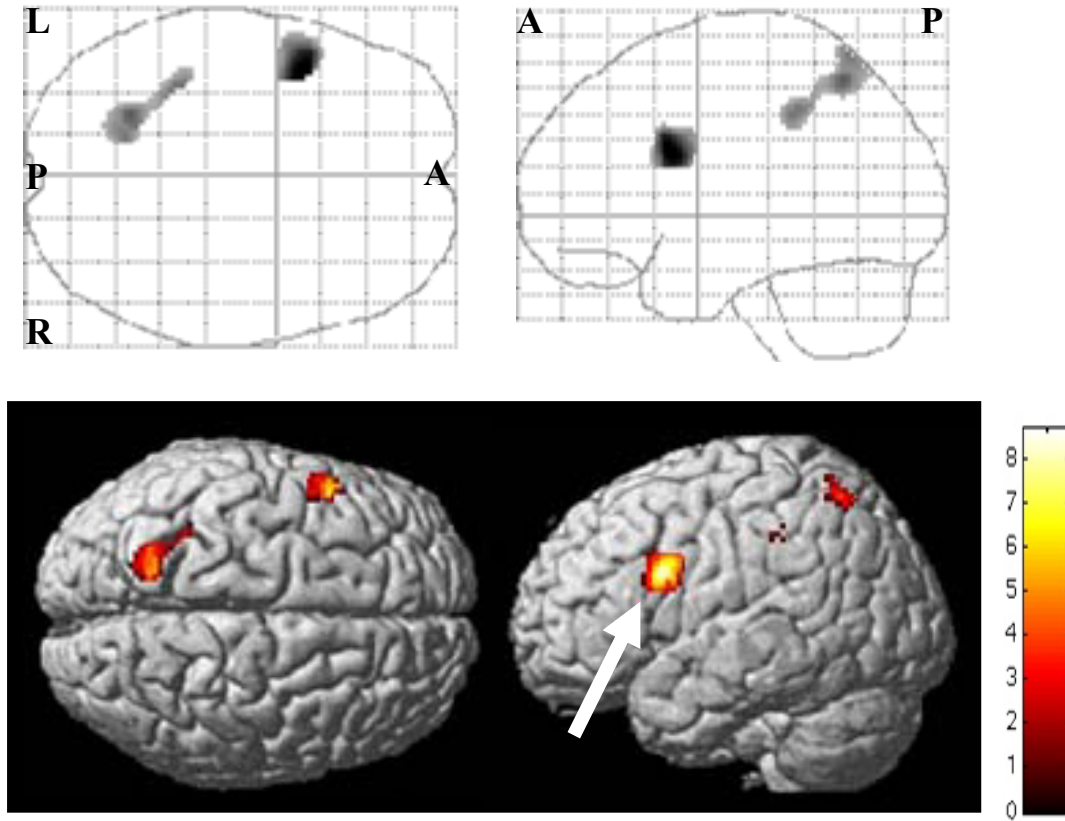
Main effect of task (EFT vs. CT) as reported by Manjaly et al. (2003), random effects analysis (16 subjects). All activations from the EFT vs. CT contrast (masked inclusively by the CT vs. baseline contrast), significant at a cluster-level corrected threshold of $p_{.05}$, are shown. Top row: Maximum intensity projections (glass brains). A_anterior, P_posterior, L_left, R_right. Bottom row: Activations overlaid on a rendered template brain. The colour bar indicates t-values. The white arrow points to the activation in the posterior inferior frontal gyrus that represented the starting point for the analysis in this paper.
